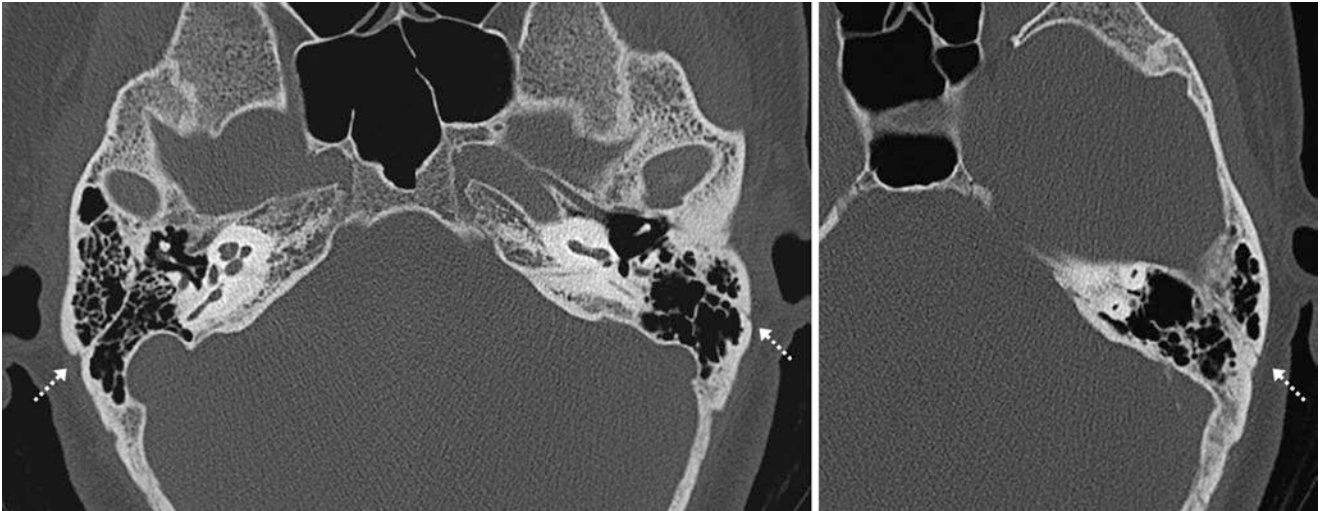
In a 40 year old a persistent petrosquamosal fissure was noted (*dotted arrows*) on thin slices from a temporal bone CT, being more prominent on the left side but also present on the right to a lesser degree
